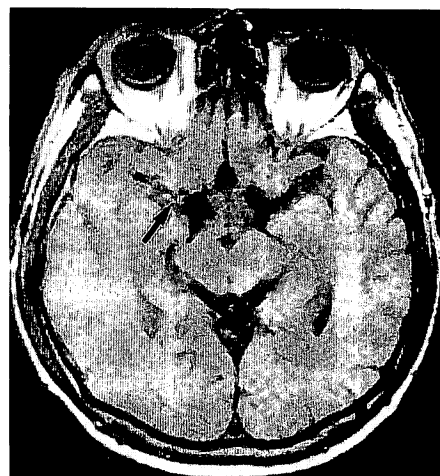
Magnetic resonance imaging (T₁-weighted spinecho image) carried out 5 days after deterioration shows the reocclusion of the right middle cerebral artery. Arrow indicates the thrombus.
